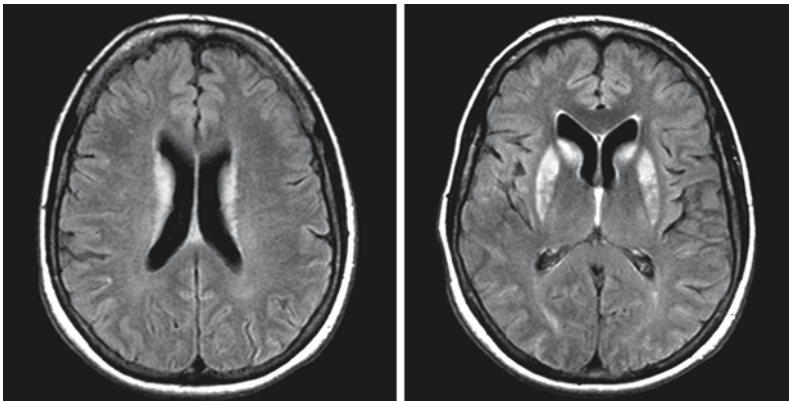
A young woman has been anoxic for at least 3 min during resuscitation. The FLAIR images show that the lesions are confined to the striatum
